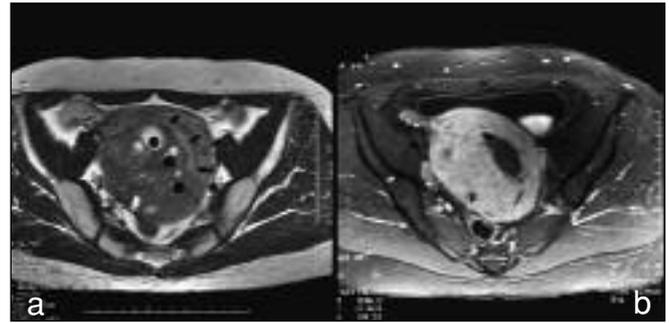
Axial MRI images of Patient 2 before and after operation. a) An enlarged uterus due to adenomyosis before operation can be seen in the T2-weighted image. The posterior wall is 7 cm thick. The thin endometrium is indicated by short arrows. The 3 irradiation sites are shown by closed circles. b) Fat-saturated enhanced T1-weighted image one month after operation, showing an avascular area in the lining of the uterine cavity with the posterior wall shrunken by half.
